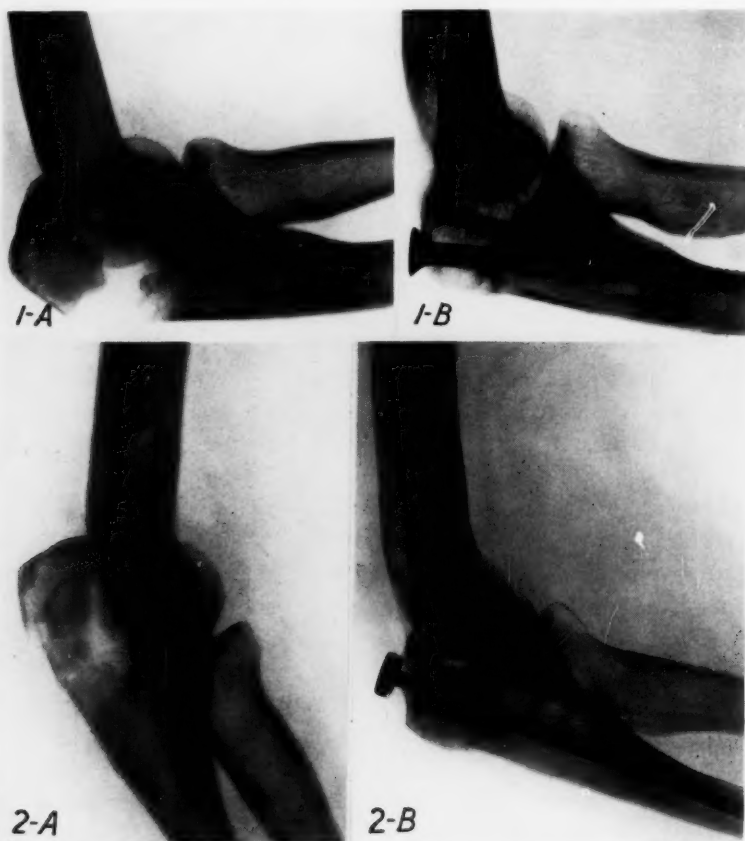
Patient H. S.: (A) A transverse fracture of the olecranon with separation of the fragments. (B) Postoperative roentgenogram showing fixation of the fragment with a longitudinal screw.
